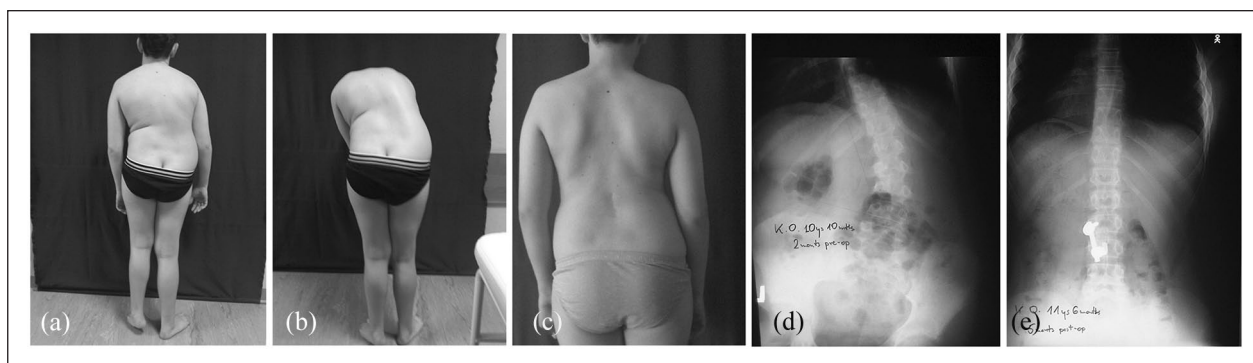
A 11-year-old boy with a 6-month history of stiff and painful lumbar spine presenting a right-sided thoracolumbar curvature with no rotation or compensatory curve (a–c), initially managed as “scoliosis.” Left sublaminar L2 osteoid osteoma of 1.5 cm diameter was identified on scintigraphy and CT scans, and was uneventfully resected; the left lamina reconstruction using local bone graft stabilized by a left L2 pedicular screw connected to sublaminar hook placed on the same L2 vertebra was performed with the aim of avoiding fusion of any articulation. Surgery followed by a 3-month cast immobilization resulted in resolved pain and scoliosis, restoring a full range of motion at a 5-month follow-up (d and e).
